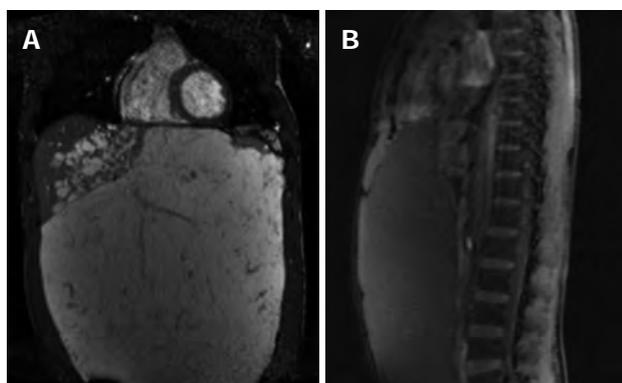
Coronal (A) and sagittal (B) views of the hemangioma from magnetic resonance imaging.
